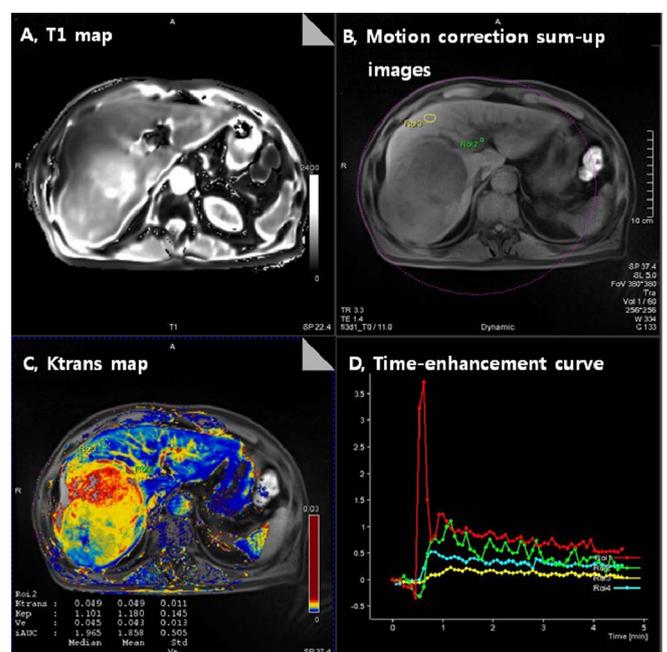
DCE-MRI of a patient with HCC
